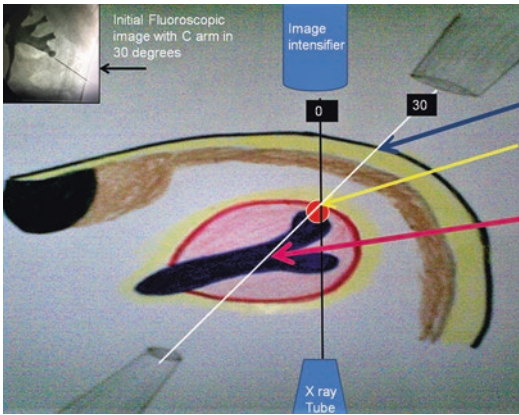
With the C arm tilted at 30 degrees, if a needle tip gets positioned anywhere on the imaginary line (white) between X-ray tube and image intensifier, it appears in the obtained image on fluoroscopic monitor that the needle tip has exactly reached up to the target calyx (Insert). Now, leaving the needle wherever it is, if the C arm is brought to 0 degree position, and a new image is obtained, the actual superficial or posterior needle (Blue) is seen lateral to the target calyx, while the actual deeper or anterior needle (Red) is seen medial to the target calyx, in the new image. The position of the needle, which is exactly on the target (Yellow), remains absolutely unchanged in both the images, whether C arm is in 30 degrees or 0 degree position
